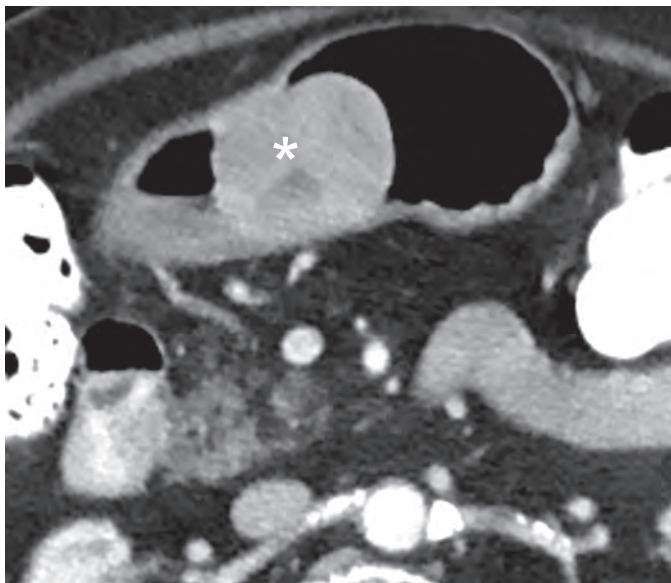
Gastrointestinal stromal tumor with high mitotic activity on CT. Axial CT scan shows a sharply circumscribed heterogeneous mass (asterisk) in the gastric antrum. This heterogeneity on CT should suggest a more high-grade lesion with areas of necrosis.
